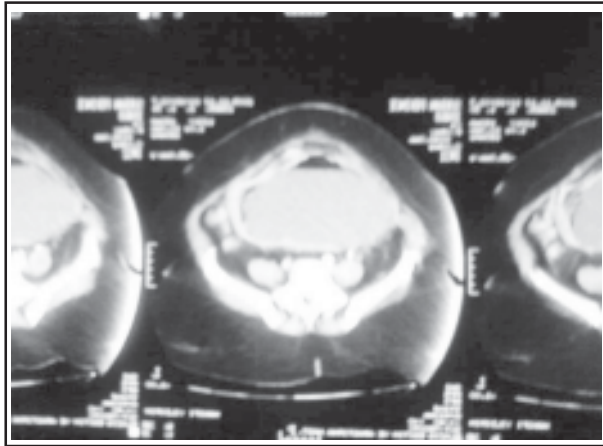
Another view of an abdominal CT scan showing a 20 by 10- by 5-cm fluid collection in the abdomen.
